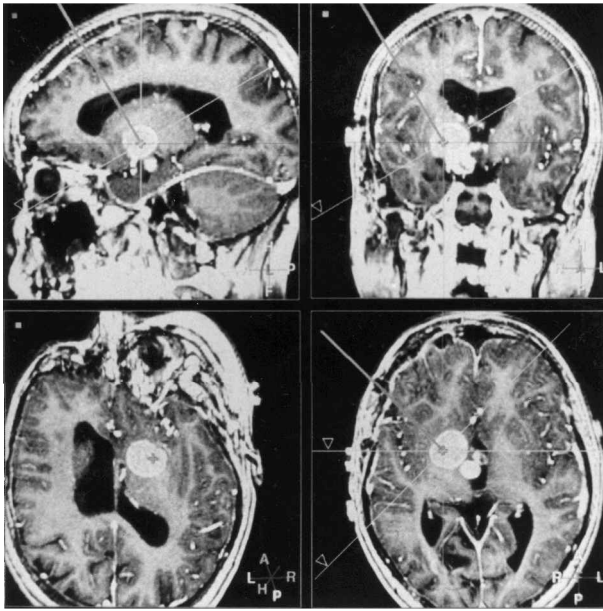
MR images from a case in the frameless stereotactic biopsy series. The pointer tip (at the skin surface) is extended with virtual pointer elongation to display the target and trajectory for biopsy. Sagittal, coronal and axial reformats reveal the detailed anatomy of the target site, whilst the perpendicular pointer view (lower left image) allows the surgeon to 'walk' along the trajectory to the target and beyond.
